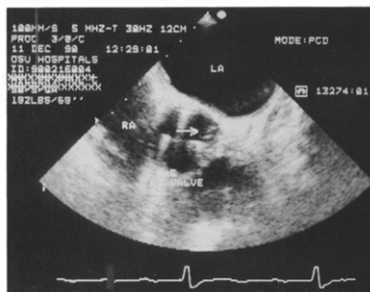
Patient 23. Basal short-axis transesophageal echocardiogram from a 72-year-old man with *Streptococcus bovis* endocarditis. Vegetation (arrow) is located at the posterior aspect of the sewing ring. The patient also had an abscess that is not visualized on this frame. AO = aortic valve; other abbreviations as in Figures 1 and 2.
